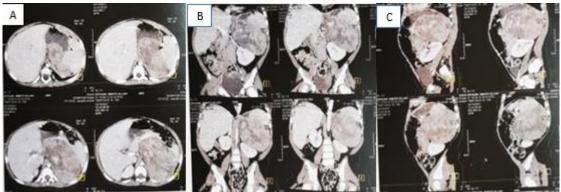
Abdominal contrast-enhanced CT scan in axial (A), coronal (B), and sagittal (C) planes demonstrating a large heterogeneous right adrenal mass with areas of necrosis and calcification, displacing adjacent organs
